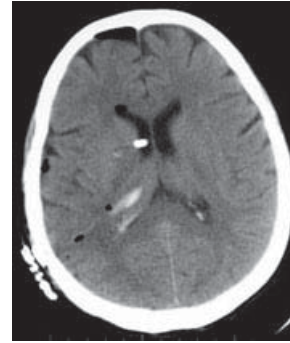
Postoperative CT of symptomatic subcortical (lacunar) infarction with haemorrhagic transformation in patient with inherited CJD receiving continuous intraventricular infusions of pentosan polysulphate (patient 3).
